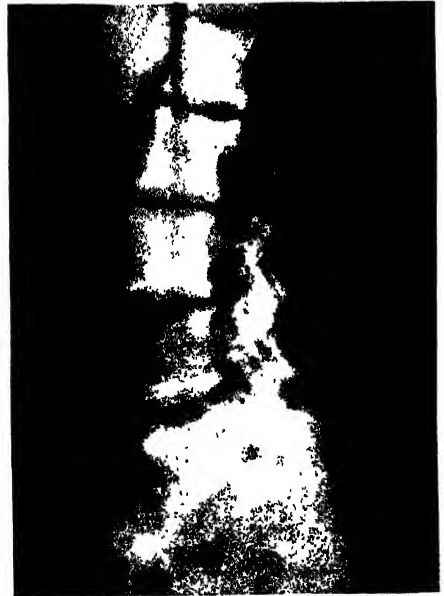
Lateral X-ray showing marked hollowing out by pressure atrophy of the back of the bodies of the lumbar vertebra by a large tumour of the cauda equina extending throughout the lumbar theca. Similar appearances may also occur in the body of the sacrum.
